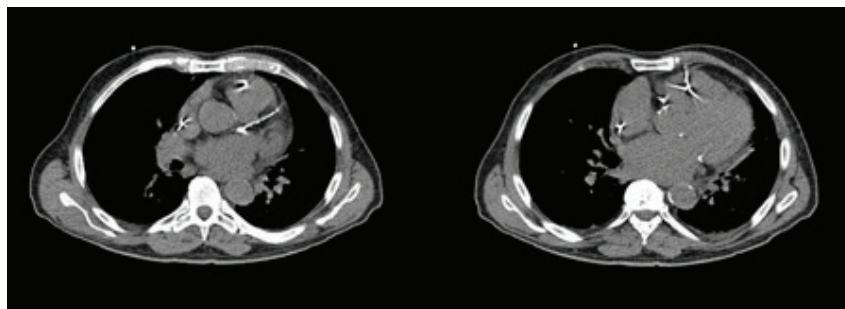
Non-contrast CT images show severe calcification throughout the LAD and multiple focal calcifications in the RCA and LCX.
